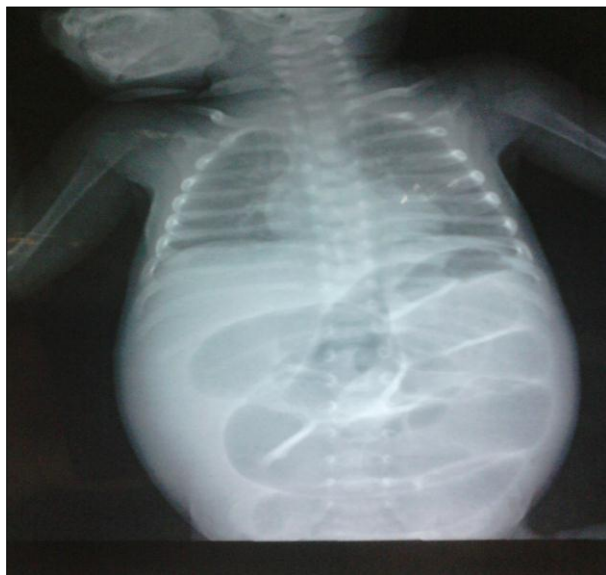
A supine radiograph showing dilated small bowel loops with absent colonic gas in distal small bowel obstruction.
